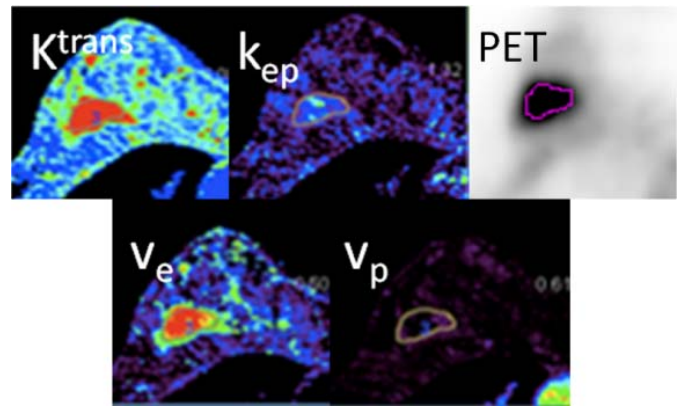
Simultaneously acquired axial DCE-MRI pharmacokinetic parameter maps and PET image of a Her2/neu+, Ki67+, PR+ right breast cancer
